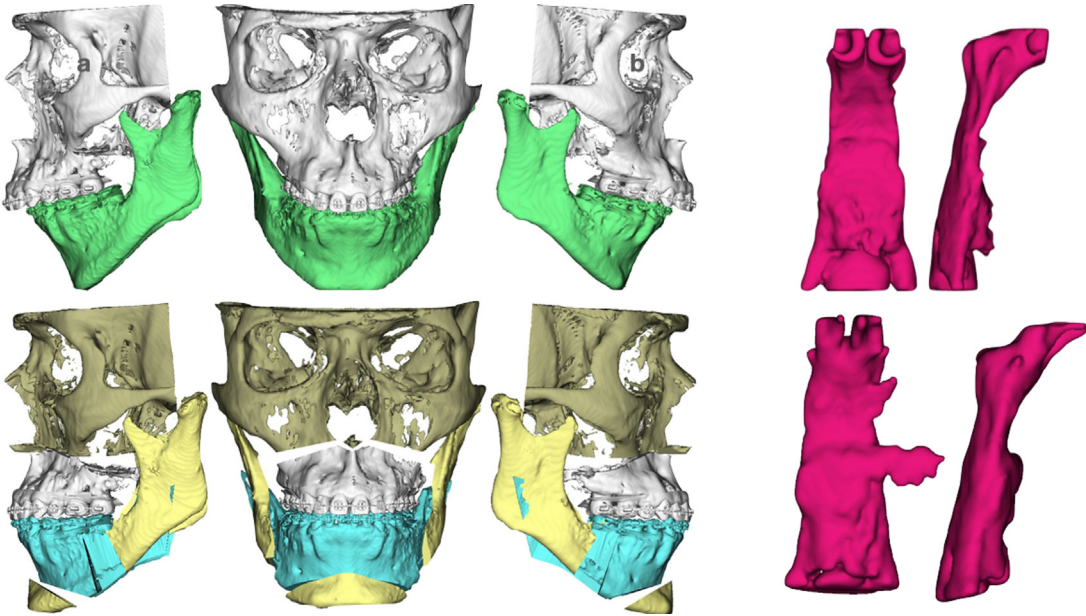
Preoperative and postoperative CBCTs showing enlargement of the upper airway after orthognathic surgery planned according to the BL protocol with forward and counterclockwise movement of the maxillamandibular complex.
